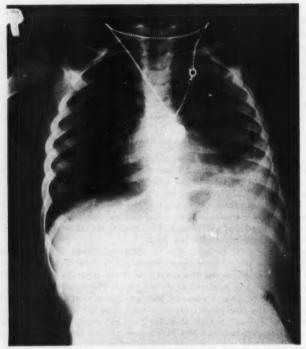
Roentgenographic examination of the chest in the anterior-posterior view: Note an area of infiltration overlying the left diaphragm having the appearance of an inflammatory process. Fluoroscopy revealed a fixed left diaphragm.
